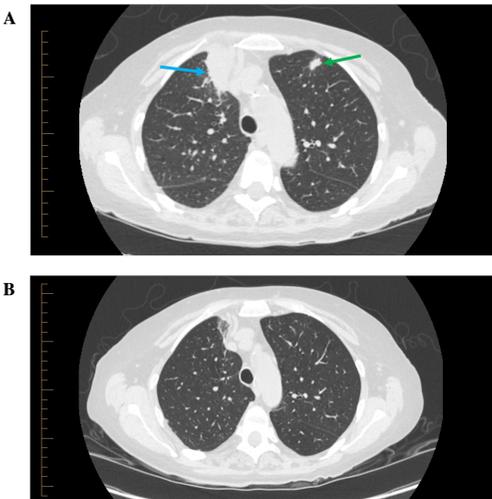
CT of the chest before and after treatment with prednisone.
